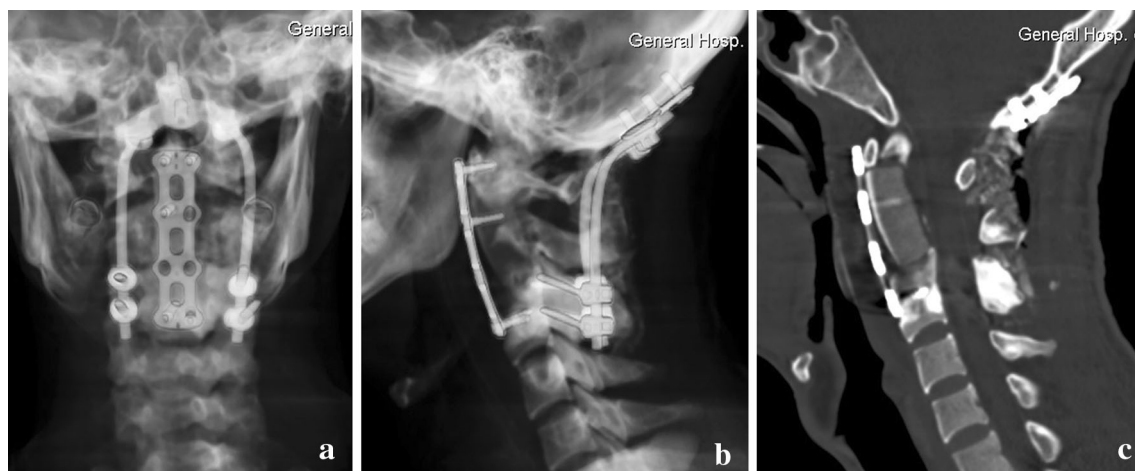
a, b The postoperation cervical radiography shows perfect instrumentation. c The postoperation cervical reconstruction CT image shows the neoplasm has been removed and replaced with the bone implant
